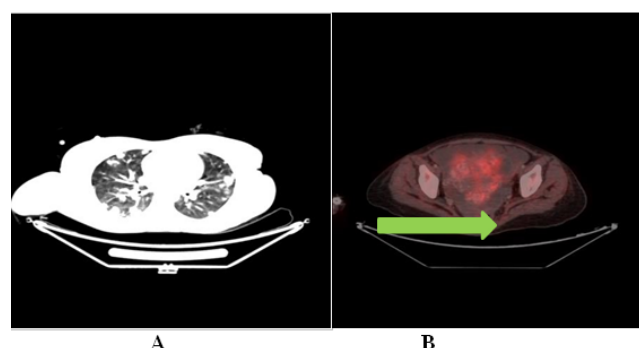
Radiological Investigations. A):CT lung (Extensive bilateral metastatic nodules in lung parenchyma)
